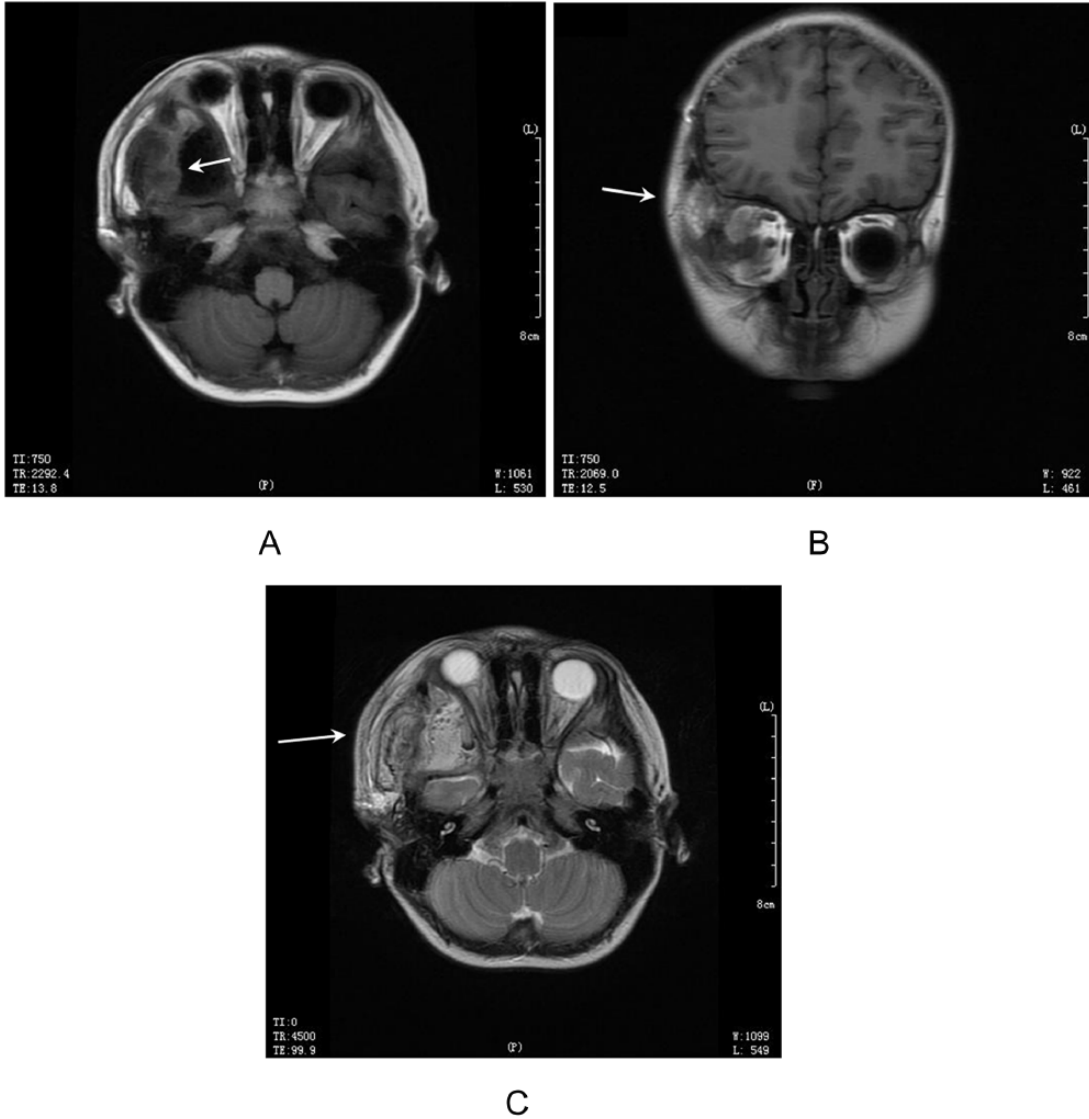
Magnetic resonance imaging of the orbit demonstrates a mass with mixed long T1 and long T2 signals in the right retrobulbar region outside the muscle cone: (A, B) T1-weighted and (C) T2-weighted image.
